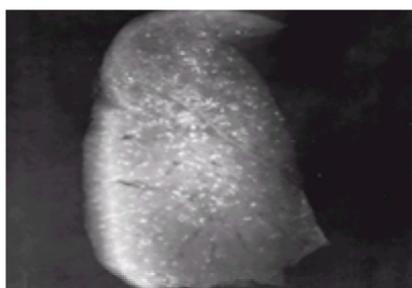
Radiograph of a large lung section from a subject with stannosis. Death was caused by carcinoma of the prostate, not by stannosis.
